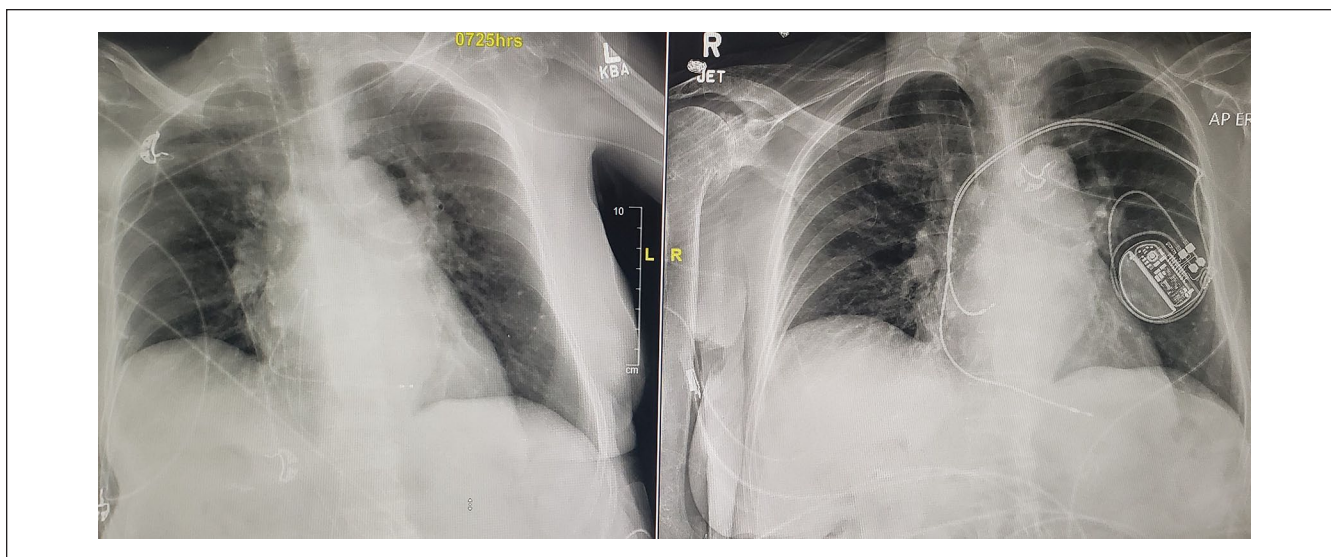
Depicting patient's chest x-ray on admission (left) and after the placement of pacemaker (right).
